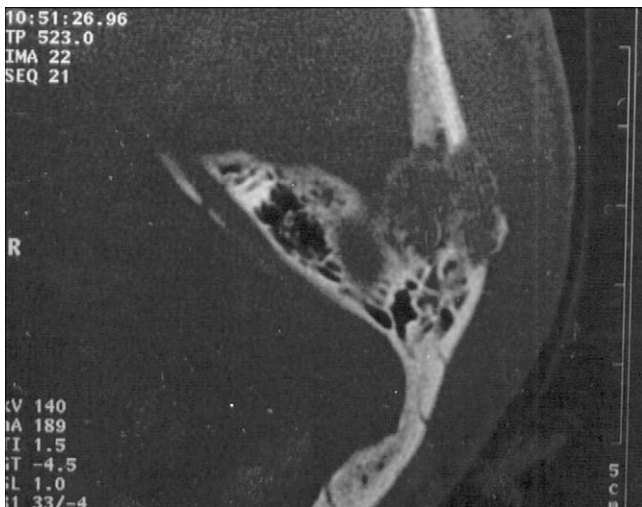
Axial CT scan of temporal bone showing a 4-cm lytic lesion of the left mastoid extending to the temporal squama.
